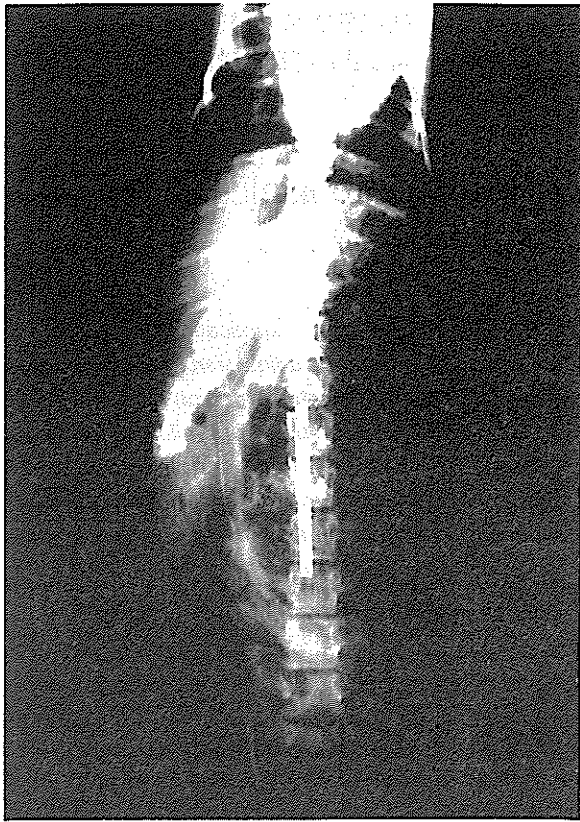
AP roentgenogram of lamb after the operation. 8 segments were immobilized by interspinous segmental instrumentation in thoracolumbar area.
